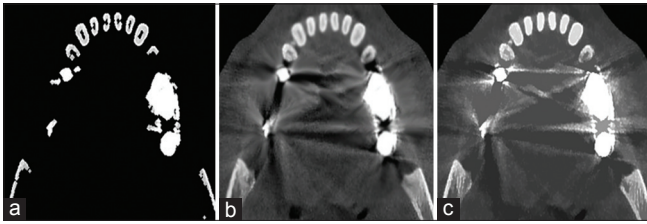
Extracted information from dental cone beam computed tomography image using (a) teeth extraction, (b) streaking artifact reduction, (c) cavity filling
